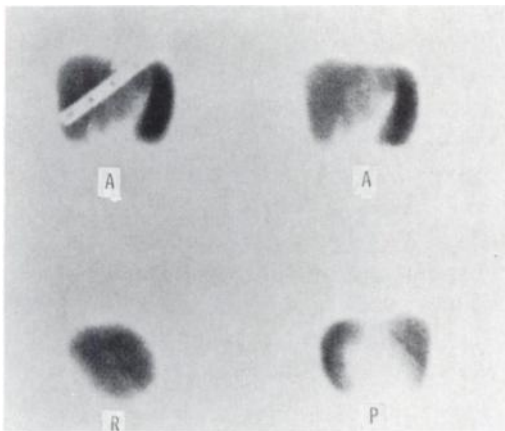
Liver-spleen scintigram showing splenomegaly and increased splenic uptake of tracer. Spleen measures ~15 cm on anterior image.
